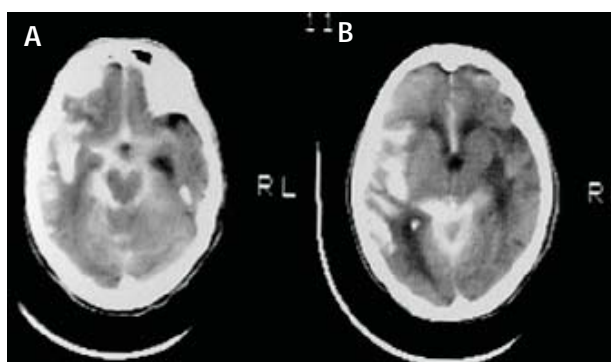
CT scan axial slices at the level of the cerebral peduncles (A) and the sylvian fissure (B). Note the high-density signal from the right sylvian fissure (pictured in both images on the left side of the scan) and the interhemispheric fissure. The brain stem is completely surrounded by high-density signal. The ventricular system is not filled because blood and contrast are in the subarachnoid space.
